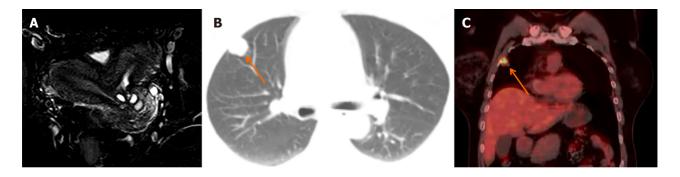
Imaging of the patient with Herlyn-Werner-Wunderlich syndrome complicated with vaginal clear cell adenocarcinoma. A: Axial T2weighted magnetic resonance imaging obtained after surgical excision of the oblique vaginal septum demonstrates uterus didelphys with two separate uterine cavities, typical of Herlyn-Werner-Wunderlich syndrome. There are also multiple Nabothian cysts in the cervix; B: Computed tomography scan of the lungs performed 4 years after radical surgery reveals a 1.8 cm nodule located in the anterior segment of the upper lobe of the right lung, suspicious for metastasis (arrow); C: Positron emission tomography/computed tomography scan, also obtained 4 years post-radical surgery, shows increased fluorodeoxyglucose uptake in the right lung nodule, indicative of active metabolic activity and consistent with metastatic disease (arrow).
